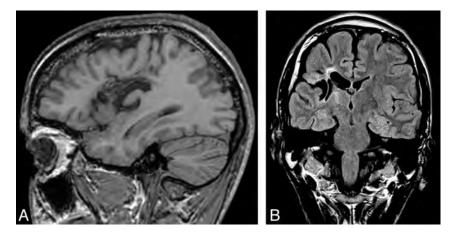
Sagittal TI and coronal FLAIR MR imaging of a 53-year-old man with a history of trauma in whom right fronto-temporo-insular epilepsy (definite) developed. Encephalomalacia and atro-phy involve the insula, frontal operculum, and superior temporal gyrus.
